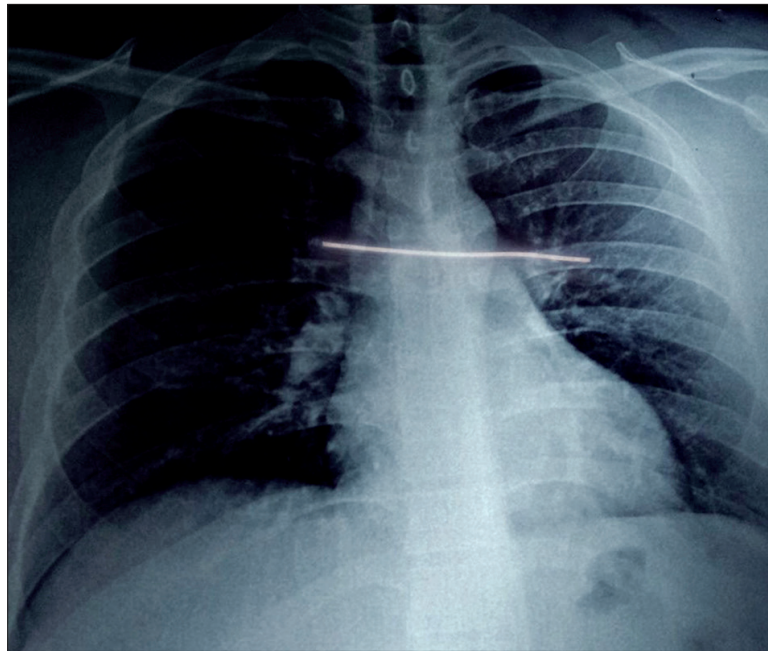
Initial radiograph of the patient
